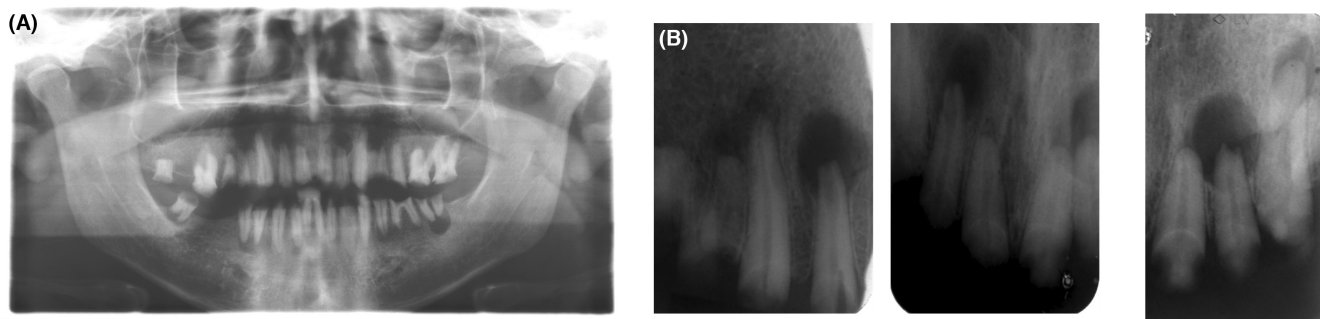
(A, B) Preoperative panoramic and periapical radiographs showed periapical lesion of maxillary anterior teeth.
